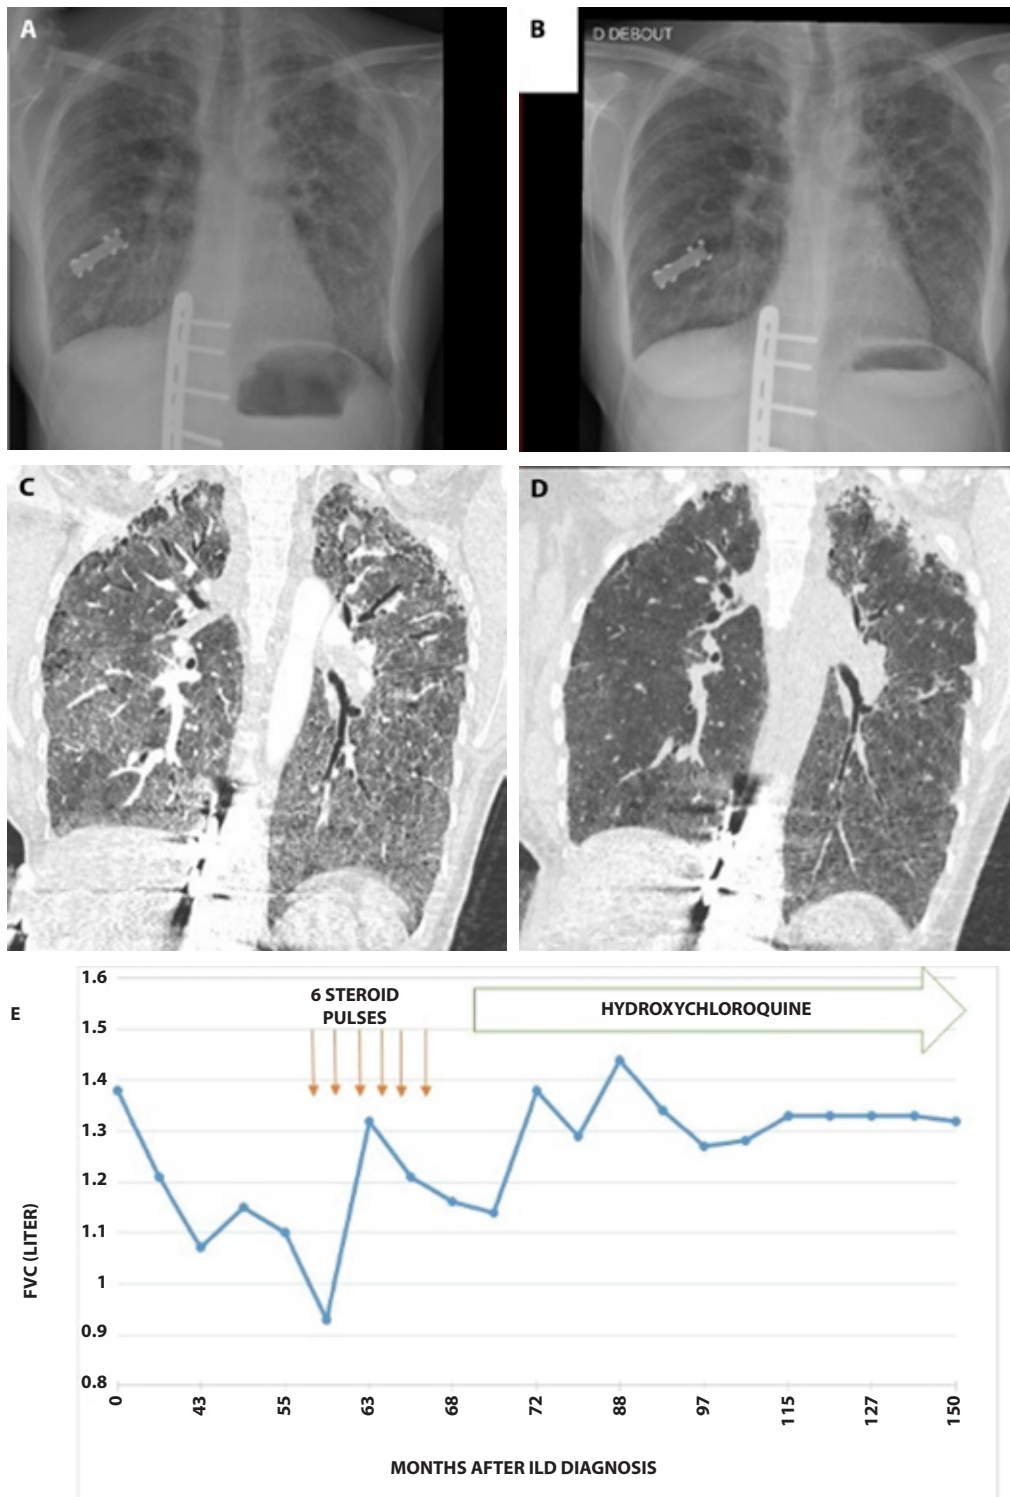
Comparison of thoracic radiographs between the 60th (Fig. 1a) and 72nd month after ILD diagnosis (Fig. 1b). Comparison of thoracic CT in parenchymal window between the 58th (Fig. 1c) and 72th month after ILD diagnosis (Fig. 1d). Evolution before and after initiation of treatment by hydroxychloroquine of FVC (liter, Y axis) in the patient with two *ABCA3* mutated alleles during the 150 months after the ILD diagnosis (months, X axis) (Fig. 1e).
